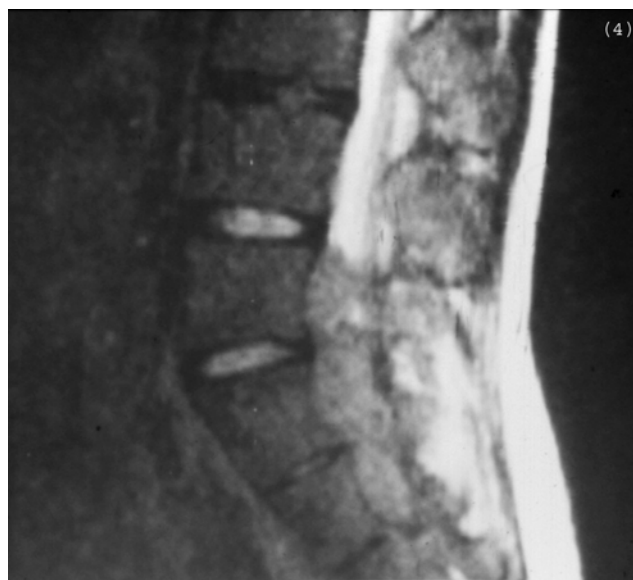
A) Mid-sagittal T2-weighted MR image of the sacral spine showing a presacral mass and an intraspinal epidural mass. B) Axial MR image of the lower thorax showing spinal canal stenosis due to epidural mass
